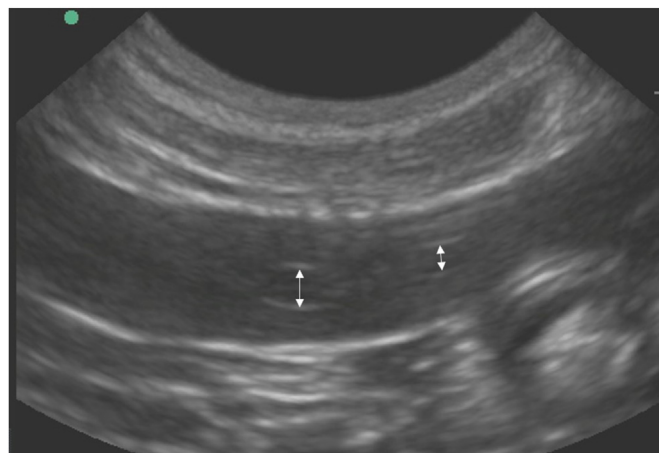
Ultrasound image of the mid-uterine body of a bitch in the luteal phase, demonstrating 2 almost spherical endometrial cysts (arrows). In both there are relatively prominent dorsal and ventral specular echoes. The cyst lumen is anechoic.
